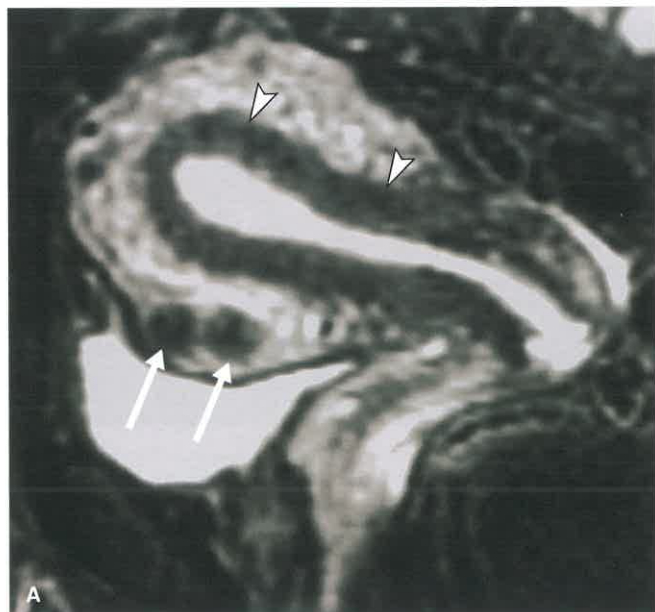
Leiomyomas. A: Sagittal T2-weighted MR image of the uterus shows two low signal intensity leiomyomas (*arrows*) in the anterior wall of the uterus. The junctional zone myometrium (*arrowheads*), having lower water content, is much lower in signal intensity than the adjacent myometrium. B: Sagittal T2-weighted MR image of the uterus of a different patient shows a very large leiomyoma (between *arrows*) with degenerative changes expanding the uterine fundus. The endometrial cavity (*arrowhead*) is greatly distorted and displaced by the leiomyoma. C: Axial postcontrast CT image shows a large sub-mucous leiomyoma (*arrow*) abutting and displacing the uterine cavity (*arrowhead*) in this woman with menorrhagia. The leiomyoma shows enhancement equal to that of the normal myometrium. The tumor is pedunculated with attachment (*curved arrow*) to the left lateral posterior uterine wall.
